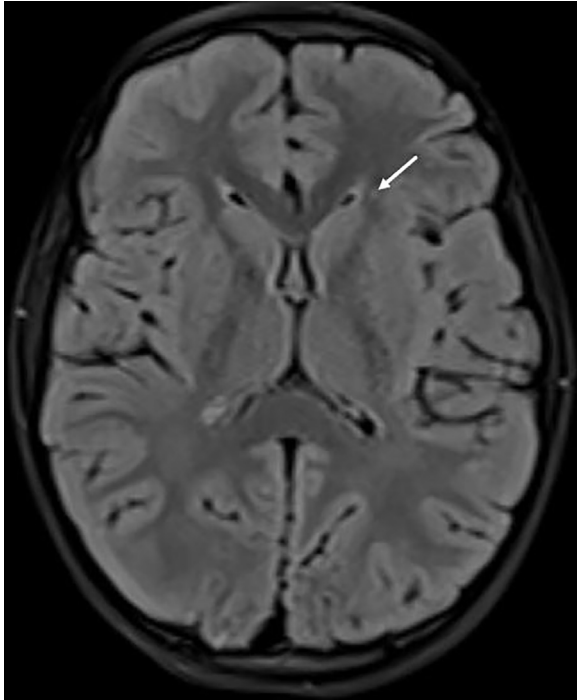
T2 FLAIR axial image of the brain, performed 18 months after the ADEM episode, showing the persistence of a single punctate WM lesion (arrow).
